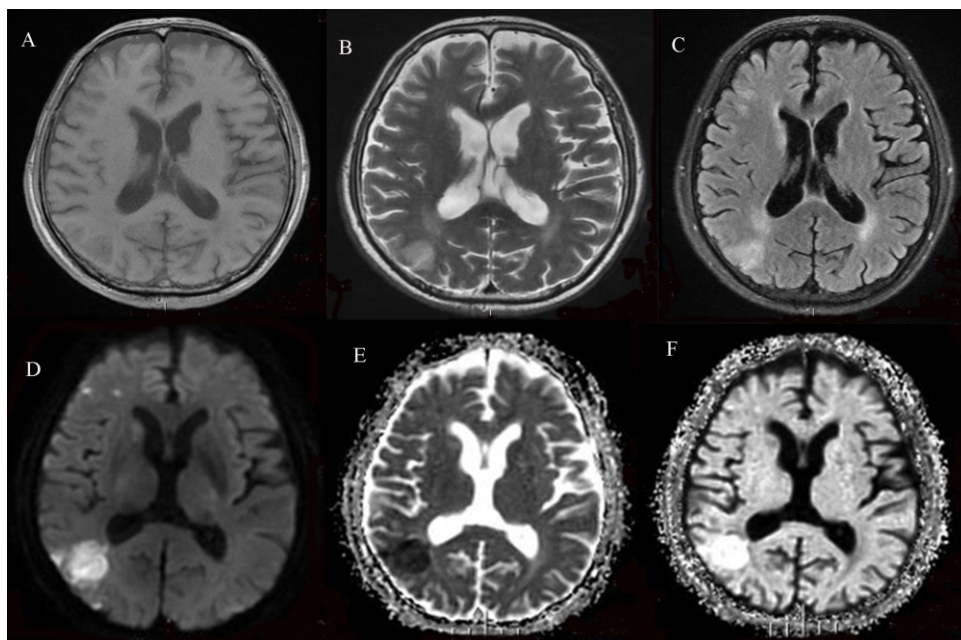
A patchy slightly hypointense and hyperintense signal in the right occipital lobe was seen on axial T1-weighted and T2-weighted images (A, B). The T2WI-FLAIR sequence demonstrates a mildly high signal intensity in the right occipital lobe (C). The lesion located in the right occipital lobe showed hyperintense signal intensity on diffusion-weighted imaging (DWI), hypointense signal intensity on apparent diffusion coefficient (ADC), and hyperintense signal intensity on exponential ADC (eADC), suggesting restricted diffusion (D-F).
